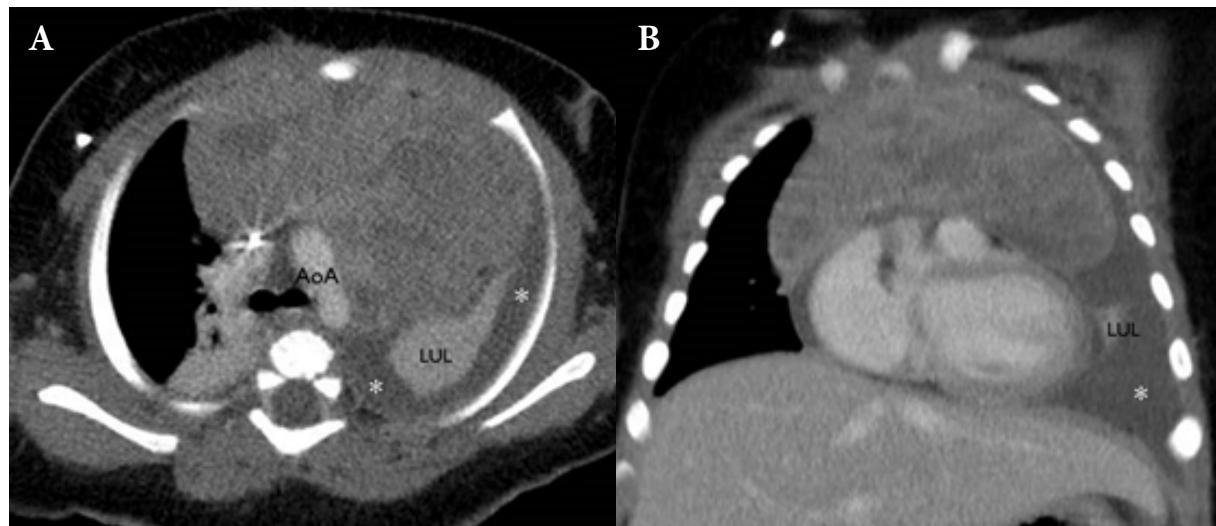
The venous-phased chest CT in axial (A) and coronal planes (B) revealed an enlarged thymus, particularly the left lobe, with preservation of a thymic shape. Measured in axial plane, transverse diameter = 79 mm (normal = 39.6 ± 5.5 mm in 4-5 months of age), right lobe thickness = 34 mm (normal = 19.5 ± 5.7 mm) and left lobe thickness = 51 mm (normal = 22.5 ± 3.8 mm) [13]. Poorly-defined multifocal areas of hypodensity (57 HU) were noted within the relatively more enhanced areas (89 HU). The left pleural effusion (*) and atelectasis of the left upper lobe (LUL) were also presented (AoA = aortic arch).
